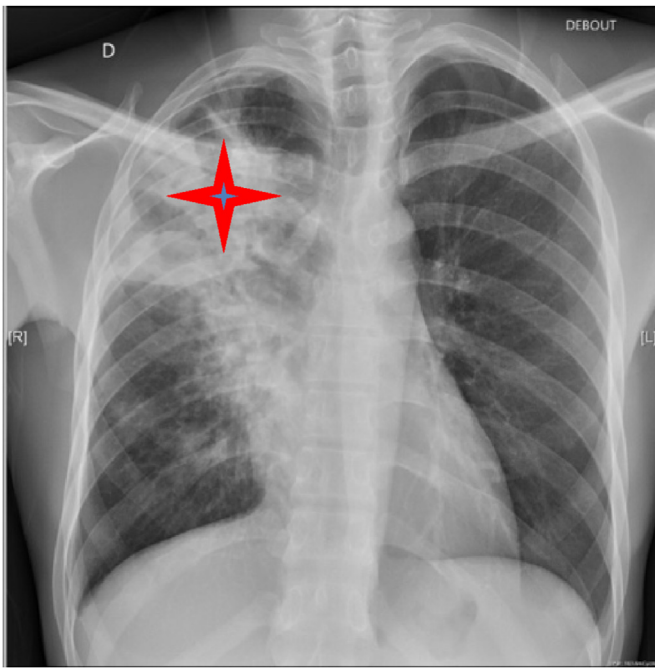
Face chest x-ray: Right hilar and apical alveolar condensation closing an air bronchogram, associated with a bubble of right superior lobe.
